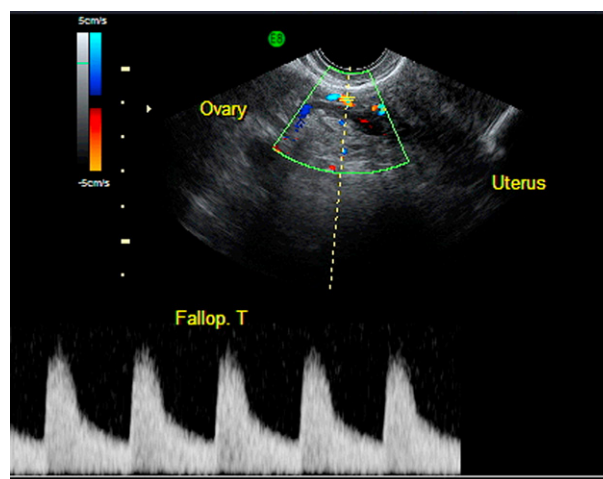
Doppler blood flow velocimetry of the fallopian tube.
